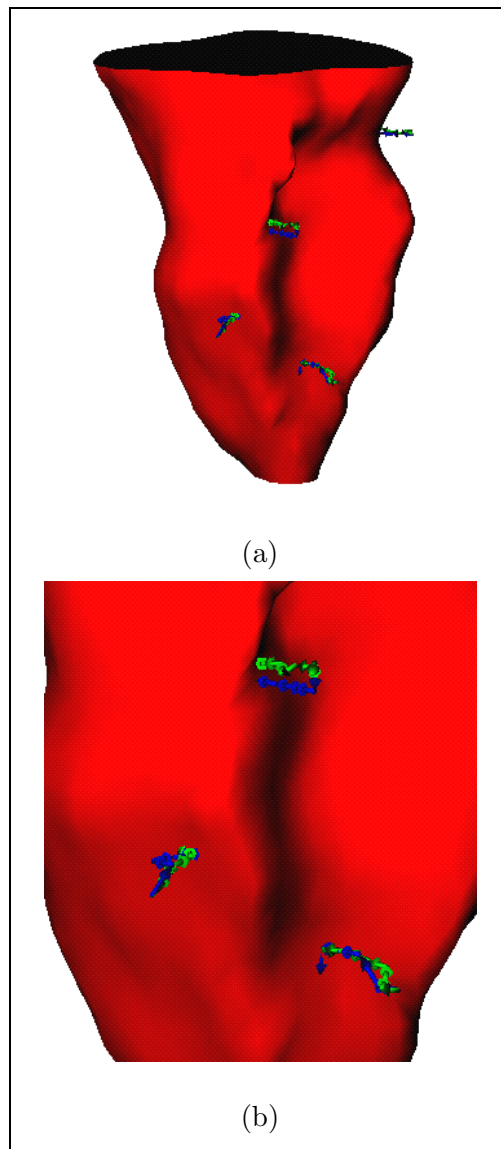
Comparison of algorithm and gold standard marker trajectories (MRI study). (a): overview of the algorithm trajectory (in blue) and the implanted marker trajectory (in green), against the endocardial surface at ES; (b): the blowup of the trajectories. The trajectories plotted are from ED to ES.
